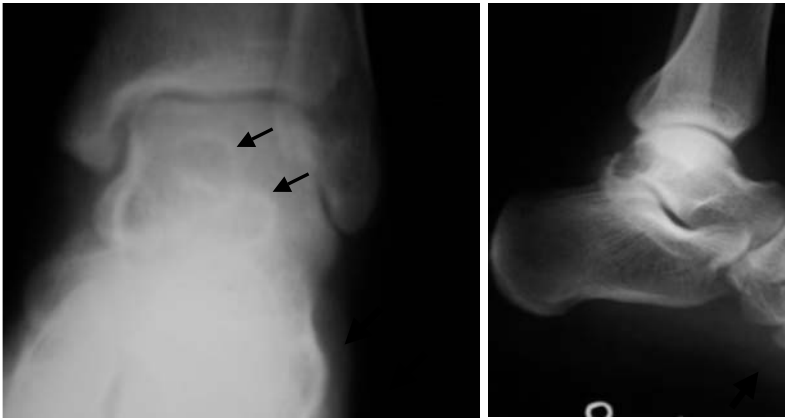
Radiograph showing lytic area in the talus (arrows) with sclerotic margins.
